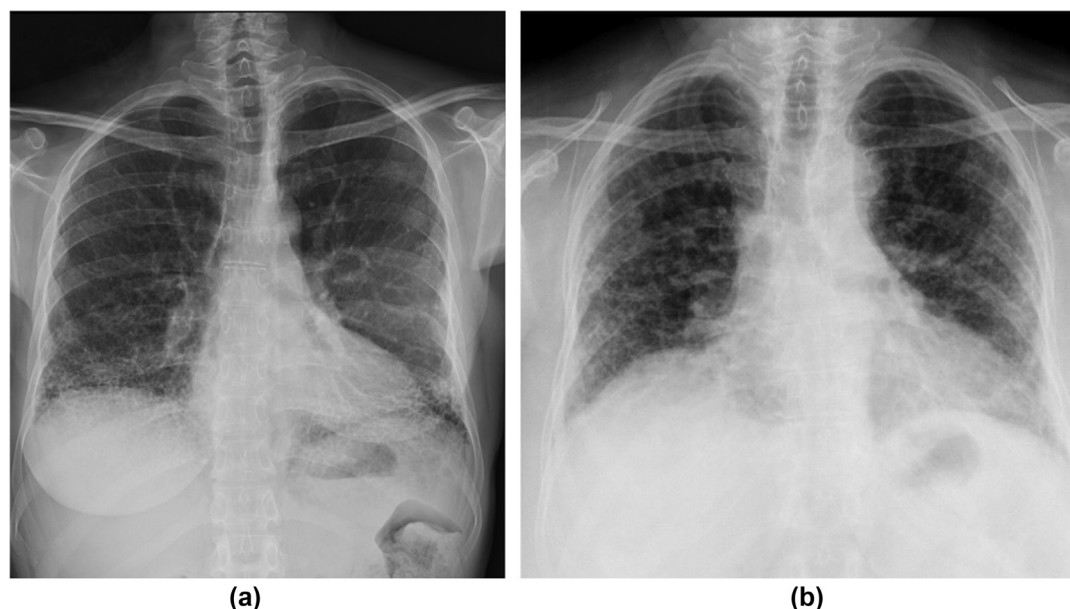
Chest radiographs of patients with CTD-ILD. Chest radiographs show basal reticular opacities in a patient with SSc (a) and basal reticulonodular opacities with reduced lung volumes in a patient with anti-synthetase syndrome (b).
